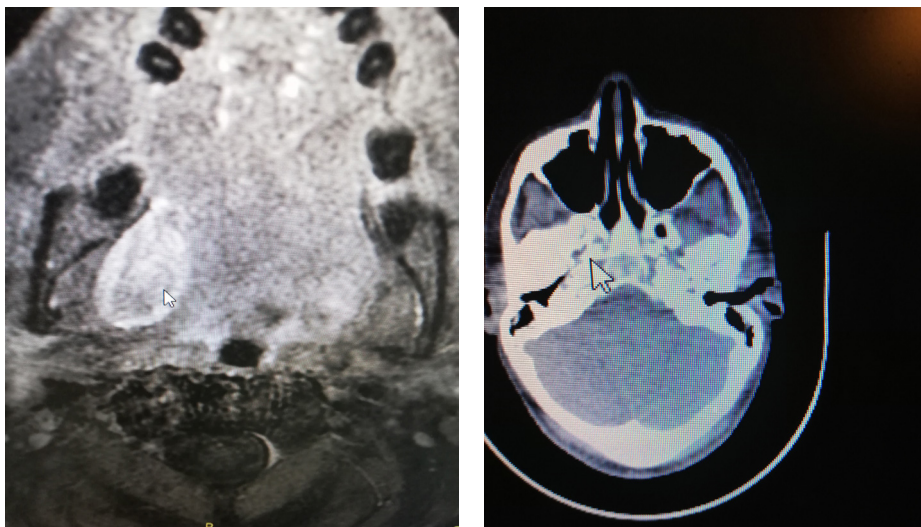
The TIO in PET (A) and MRI scan (B).
